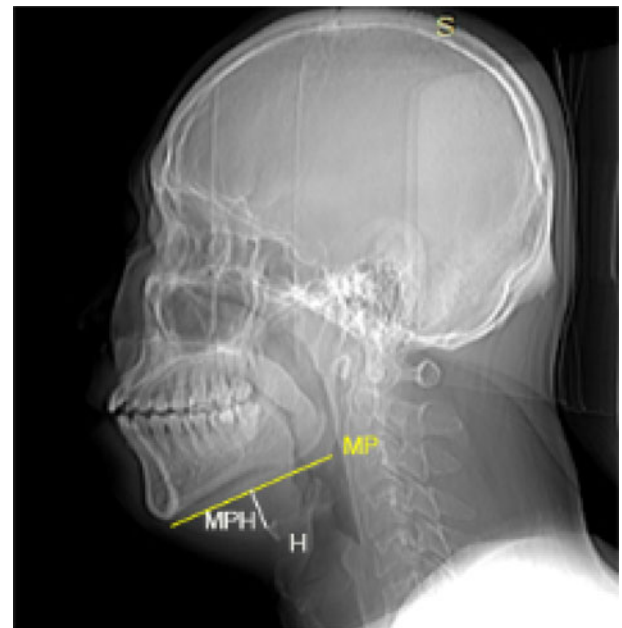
Sagittal computed tomography scan showing: hyoid (H); mandibular plane (MP, yellow line); and perpendicular distance from the hyoid bone to the mandibular plane (MPH).
